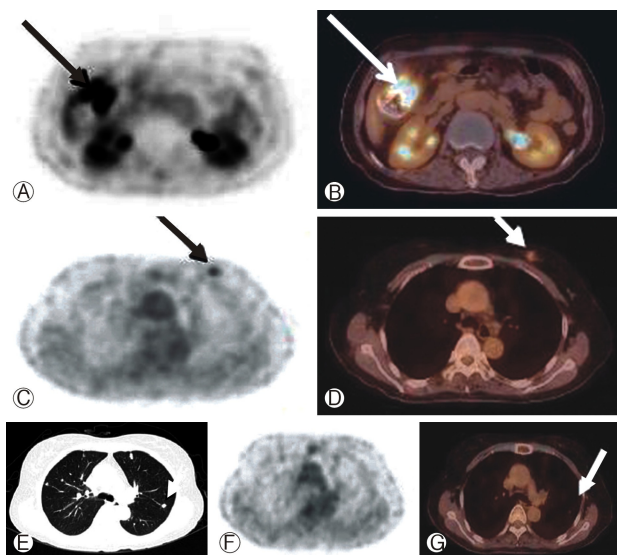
The fluorodeoxyglucose positron emission tomography (FDG-PET) scan showed a hypermetabolic lesion in the right ascending colon (A, B) and a left breast nodule (C, D), but there was no abnormal FDG uptake in the small pulmonary nodules (E-G).
